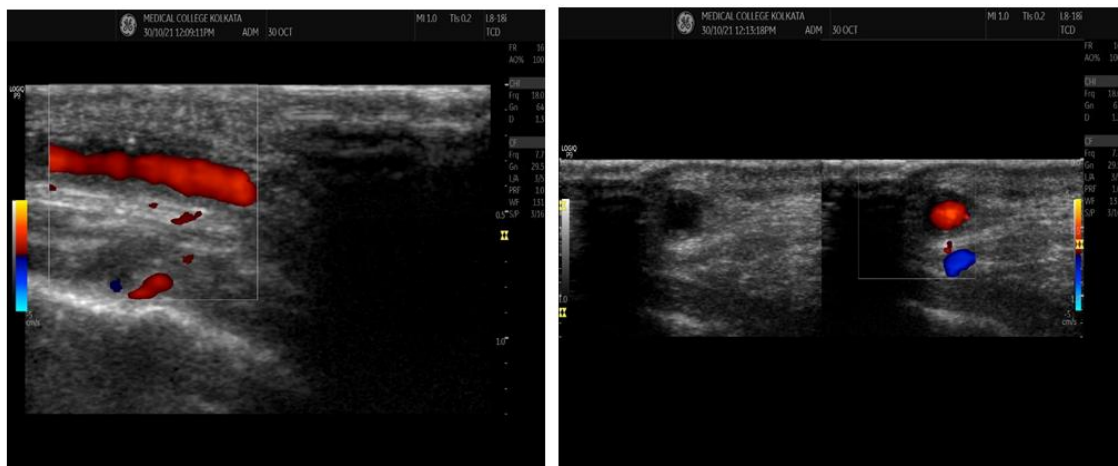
A 58-year-old female presented with left temporal headache and polyarthralgia. Temporal artery doppler showed typical pattern of circumferential hypoechoic wall thickening involving the painful superficial temporal artery. B mode and colour doppler showed edematous wall swelling of parietal part of temporal artery. Halo score was calculated to be 17 in this patient.
